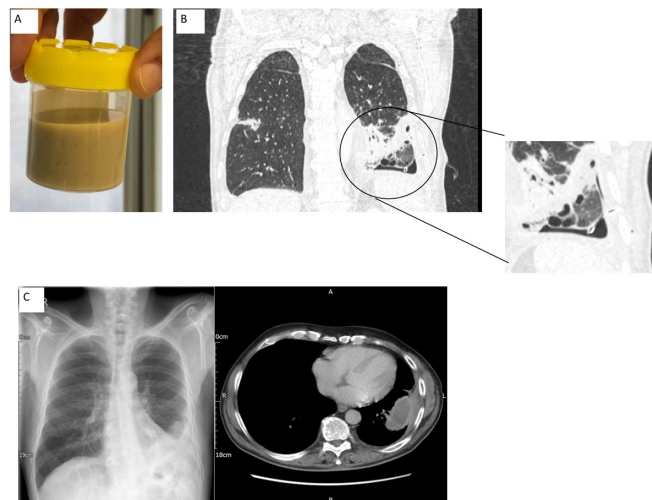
Post percutaneous intervention. (A) Purulent pleural fluid aspirated with anthracotic lung visible. (B) Chest CT with contrast, coronal cut showing chest drain appropriately sited in pleural space with underlying abscess and tissue necrosis. (C) Chest radiograph and axial CT showing excellent resolution with small thick-walled residual collection.
